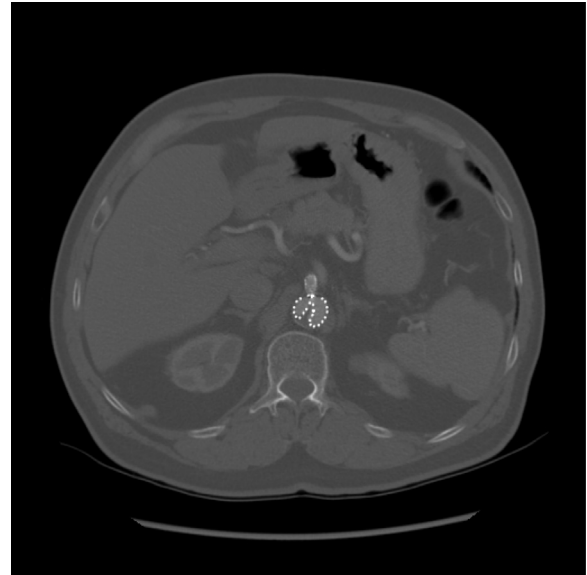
The 1-month postoperative computed tomography (CT) image showing the fenestrated graft with infolding of perivisceral segment.
